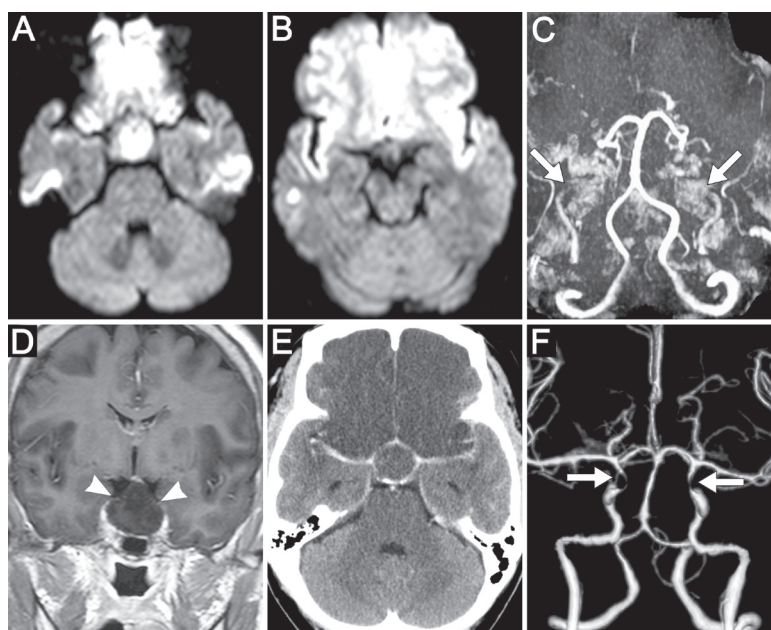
Imaging studies of patient 1 with acute bilateral ICA occlusion. (A, B) Diffusion-weighted MRI on day 2 showed acute infarctions involving the pituitary gland and bilateral frontal lobes. (C) MRA showed interruption of the bilateral ICAs at cavernous portions (arrows). (D) T1-weighted coronal view of brain MRI indicates enlarged pituitary gland (arrowheads). (E) Enhanced axial view of brain CT findings on day 3 revealed enlarged pituitary gland with acute bilateral frontal infarctions and patent bilateral MCAs. (F) Brain CTA on day 3 revealed tight stenosis of the bilateral ICAs at cavernous portions (arrows) with patent bilateral ACAs and MCAs.
